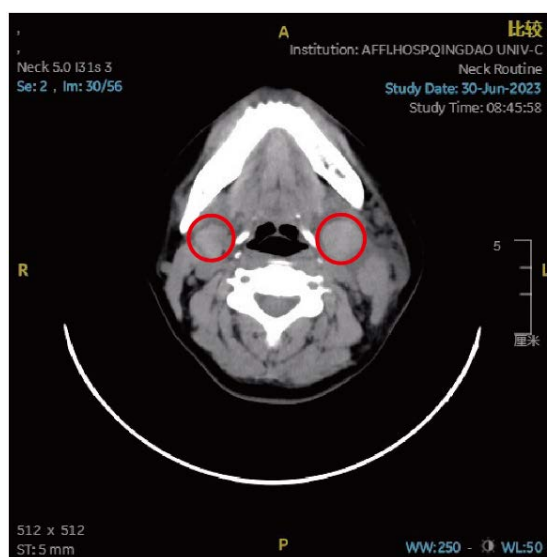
Preoperative CT, with enlarged bilateral submandibular glands circled in red
